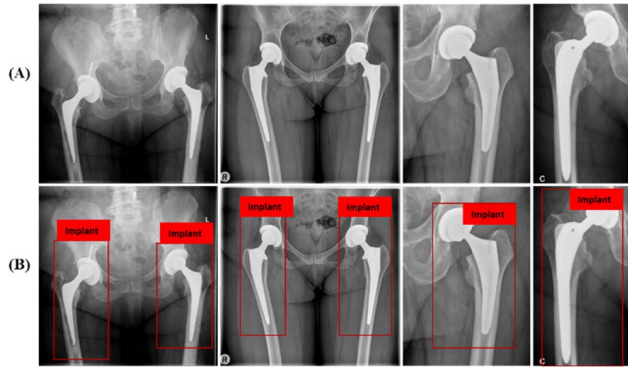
Sample images of implant detection dataset; (A) Hip implant X-ray images, and (B) Hip implant with Implant annotation.
